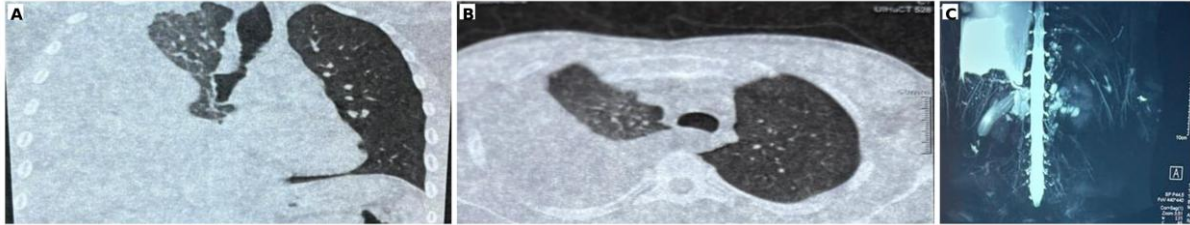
(A) Chest X-ray showing a moderate right-sided pleural effusion. (B) Axial thoraco-abdomino-pelvic CT scan confirming the right pleural effusion without a detectable mass lesion. (C) MR lymphangiography demonstrating retro-pancreatic and retroperitoneal lymphangiectasia, with no compressive mass along the thoracic duct.
